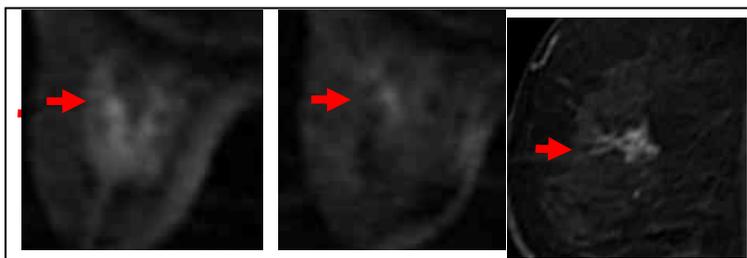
A case of ductal carcinoma in situ. The left image(b-value of 1000s/mm²) shows a nodular lesion with slightly higher signal intensity than surrounding breast tissue in the upper quadrant. Middle DW image (b-value of 1500s/mm²) shows higher contrast against the surrounding breast tissue in turn has a higher CNR than that recorded for b=1000s/mm². The contrast enhanced T1 weighted image on the right shows non-mass forming clumped enhancement, which is concordant with the high signal intensity lesion on DWI. The pathologic examination revealed low papillary type DCIS surrounded by fibrocystic disease
